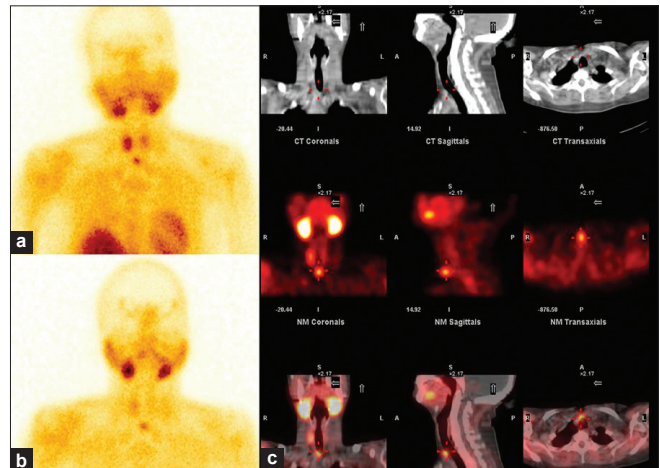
A 53-year-old female presented with raised serum parathormone; however, serum calcium and phosphorus were within normal limits. Ultrasonography neck showed features suggestive of enlarged right lobe of thyroid with three nodules with calcific foci within it. Tc99m sestamibi scan (a) early images show homogenous tracer uptake in both lobes of the thyroid (Right > Left) along with small focus of tracer uptake below the thyroid; (b) delayed images show uniform washout of the tracer from both lobes with retention of tracer in the small focus below the thyroid. (c) SPECT/CT of neck and mediastinum localizes the increased tracer uptake in the pretracheal region
